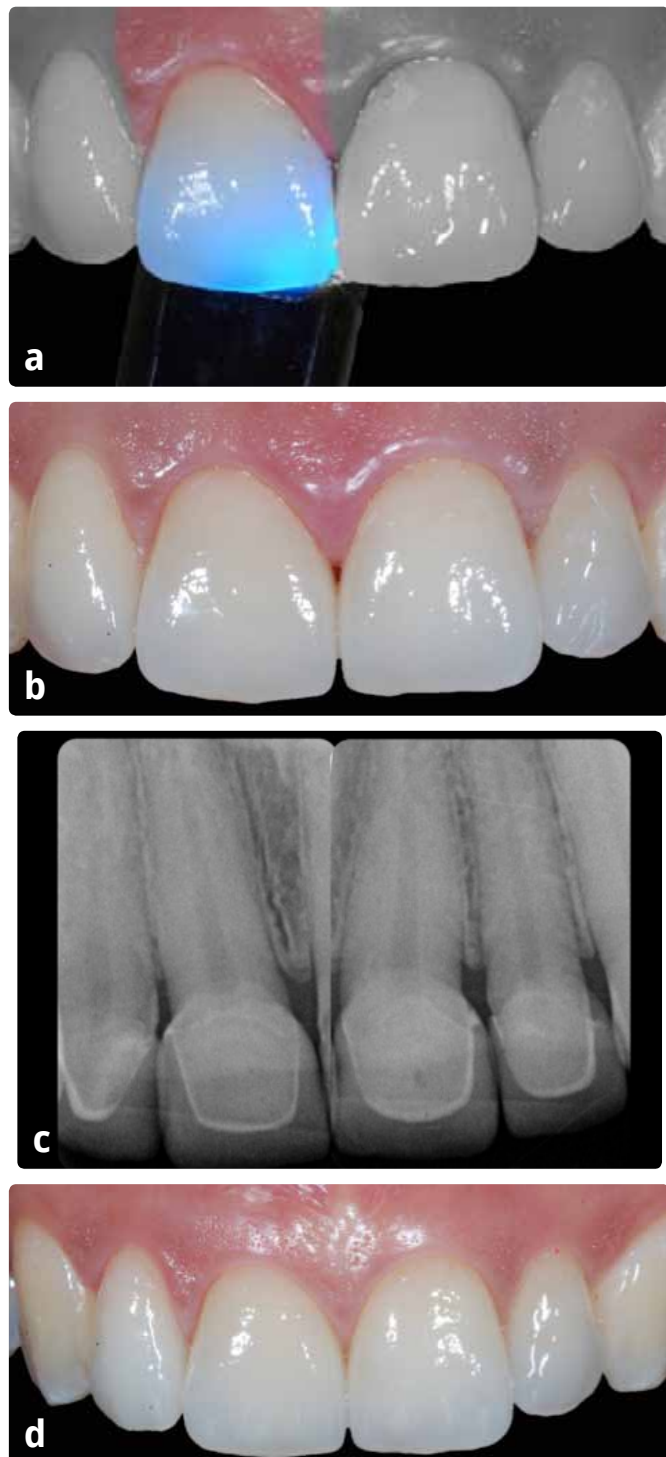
a) Monolithic lithium disilicate single crowns during cementation, b) immediately after cementation, c) x-rays immediately after cementation confirming lack of cement excess, d) crowns 1 month after final cementation.
